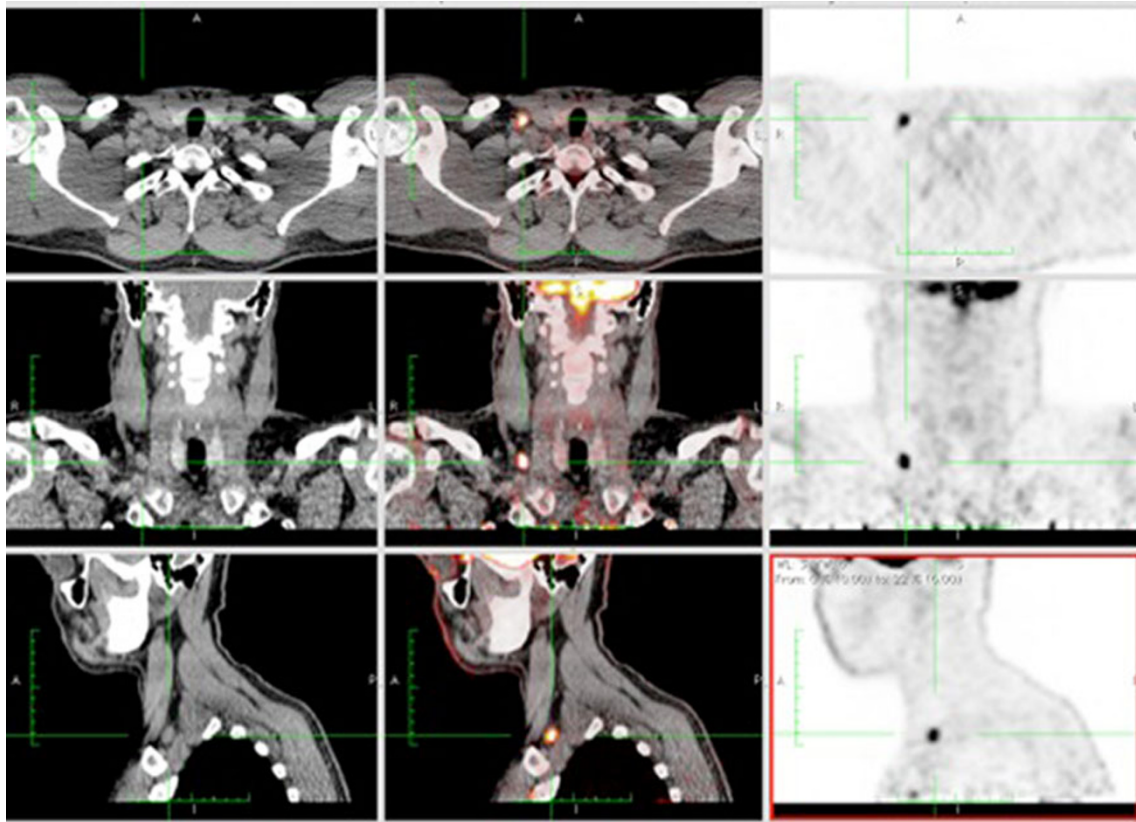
^{18}F FDG imaging to monitor cancer treatment. Computed tomography (CT, *left*), ^{18}F FDG positron emission tomography (PET, *right*) and PET/CT fusion (*middle*) images in a patient with Hodgkin's lymphoma, evaluated after eight courses of chemotherapy. Intense
